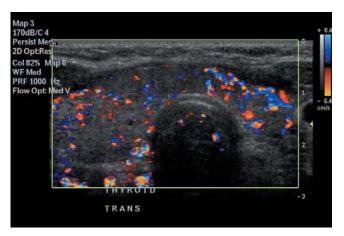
Transverse image of the thyroid showing markedly increased vascularity on colour Doppler typical of Type I AIT
